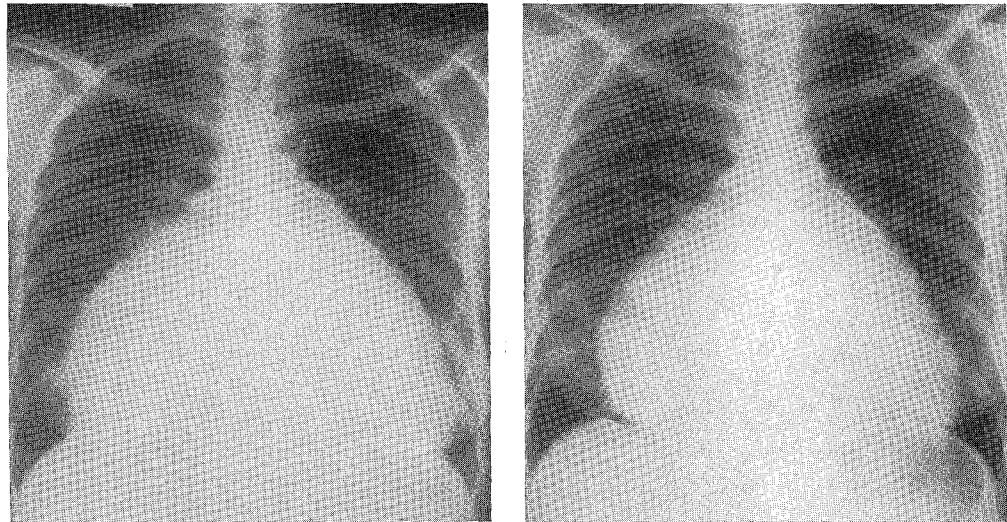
(a) Roentgenogram of the chest of a patient with severe rheumatic heart disease, causing aortic insufficiency and mitral stenosis. Before operation, the heart was grossly enlarged. The left ventricular bypass pump was used for ten days in this patient after the aortic and mitral valves had been replaced. (b) Roentgenogram of the chest of the same patient eighteen months after operation, showing notable reduction in size of the heart.
